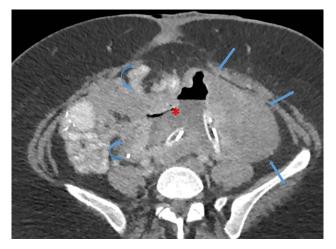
Active infection/abdominal sepsis in desmoid patient. Axial CT image demonstrating the desmoid lesion (arrows) with encasement of small bowel loops (curved arrows) and fistulation. Small-bowel content and gas centrally within the desmoid mass (asterisk). Two surgical drains within the cavity. CT, computed tomography.
